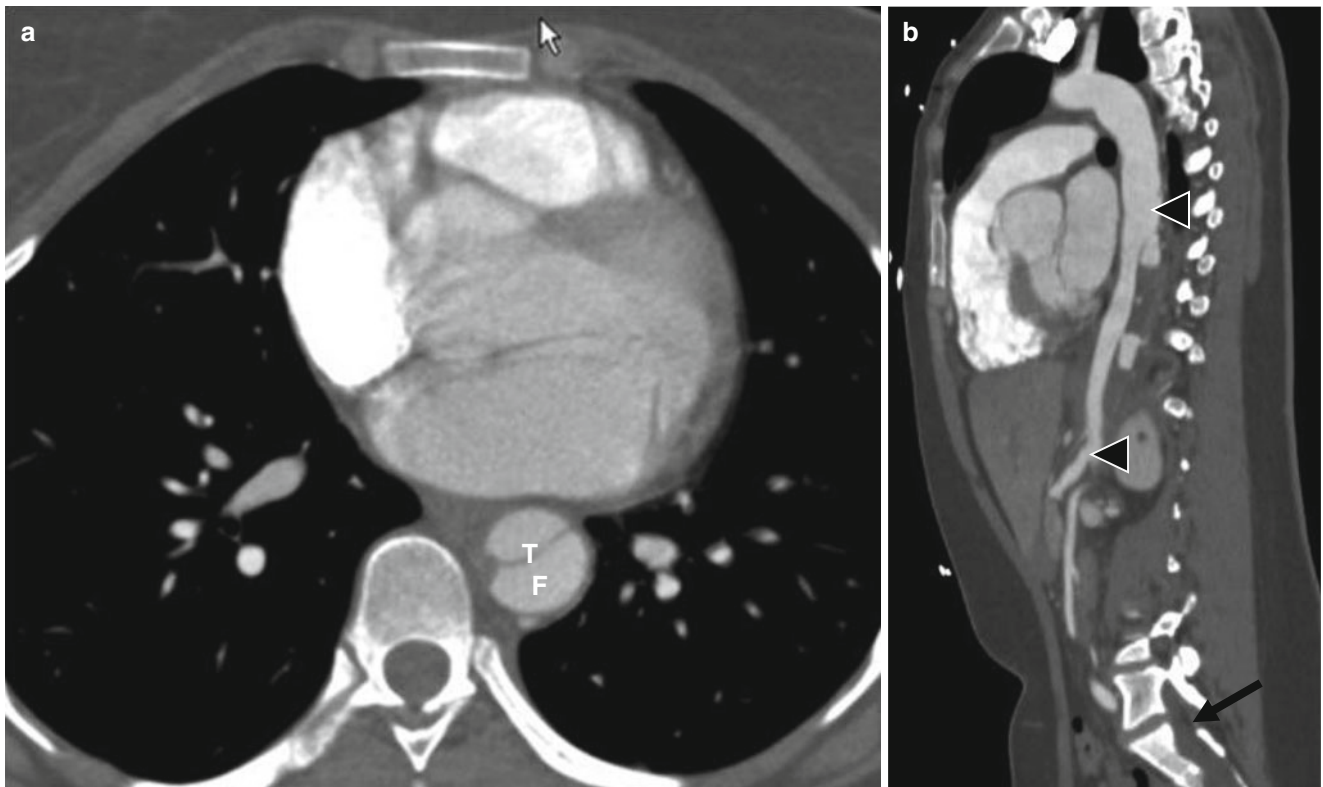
Aortic dissection in a patient with Marfan syndrome. This computed tomography scan demonstrates a type B aortic dissection (involving the descending thoracic aorta only). Panel (a) an axial view at the level of the left ventricle shows an intimal flap in the descending aorta separating the inner true (T) and outer false (F) lumens. Panel (b)
